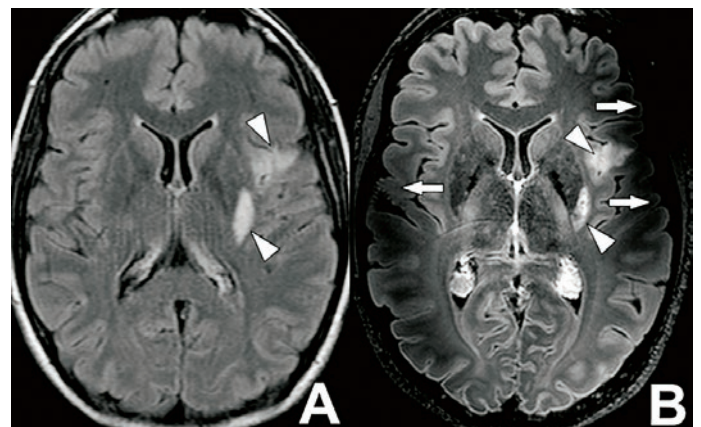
Brain MRI view at 3T (A) and 7T (B) showing artifacts at 7T
